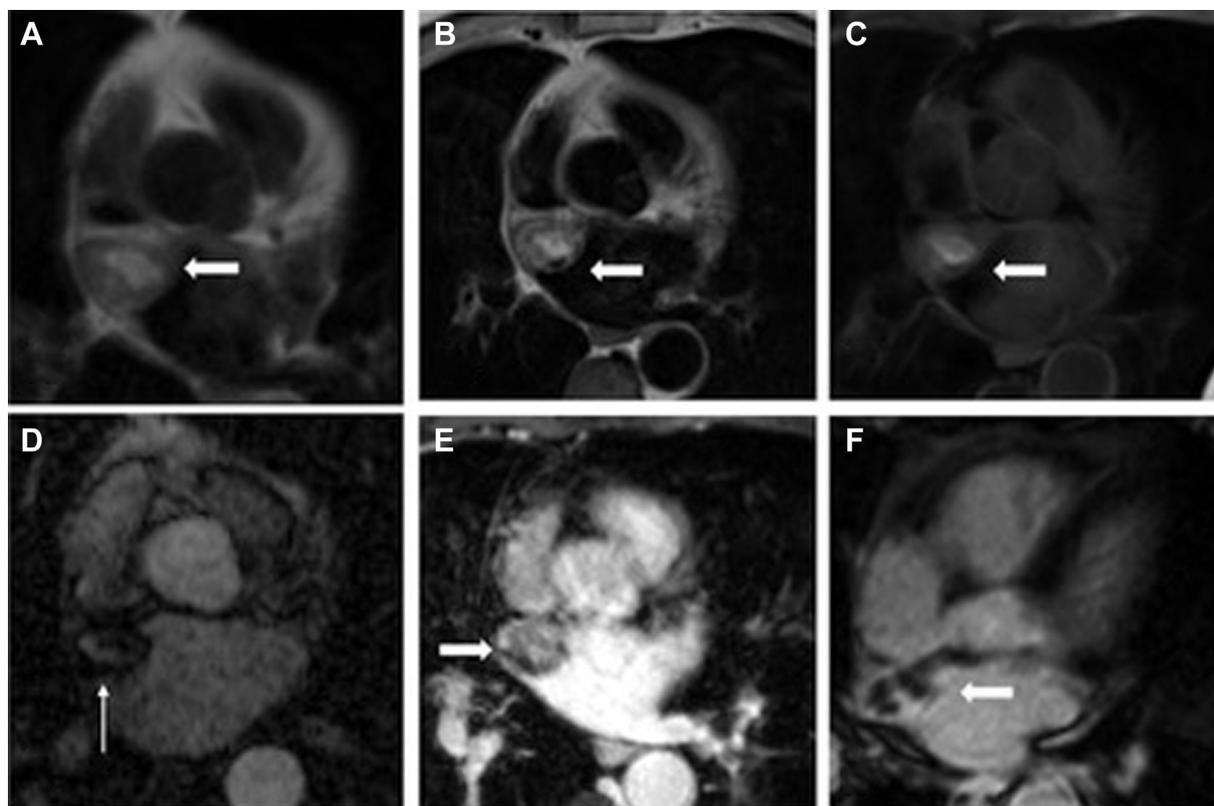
Cardiac MRI showing a thrombus (wide arrows) in the right superior pulmonary vein. On T1-weighted (A) and T2-weighted (B) axial sequences, the lesion shows heterogeneous signal with no fatty component on T1-weighted fat saturated sequence (C). On perfusion sequence (D), the center of the lesion (thin arrow) remains isointense to blood pool, related to a recanalization of the thrombus. Heterogeneous enhancement of the thrombus is shown on 3D post contrast gradient echo (E) with persistent, mild peripheral enhancement on 4-chamber viability sequence (F).
